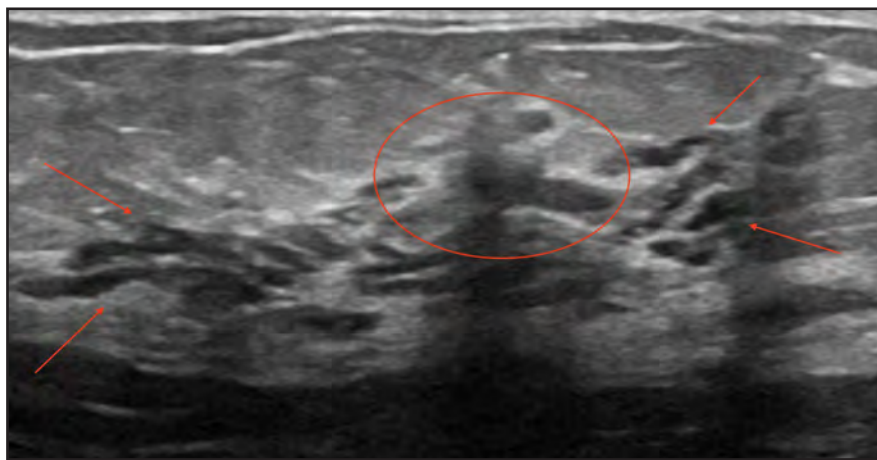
B-mode grayscale targeted ultrasound in the right breast at 12 o'clock 2 cm from the nipple in the sagittal plane.
